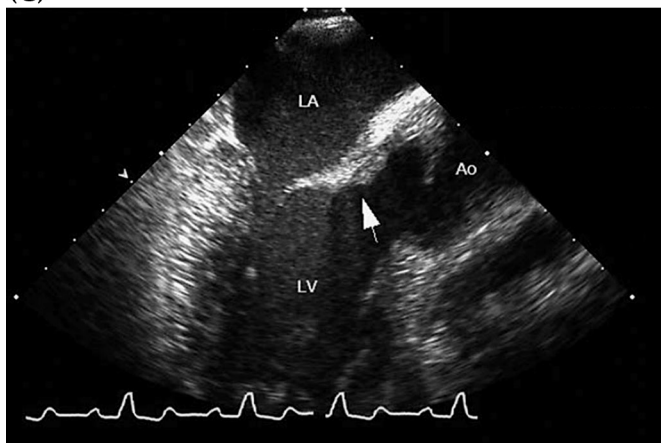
Transesophageal echocardiogram of a patient with ReA showing the aortic valve in short-axis, demonstrating diffuse thickening of the aortic wall (A; arrows) and aortic-mitral curtain (B; arrow), the so-called subaortic bump. In this particular patient, a subsequent study conducted 4 months later demonstrated massive thickening of the aortic-mitral curtain, extending to the body of the anterior mitral leaflet (C; arrow), while sparing the posterior mitral leaflet. Adapted from Novaro et al. [198].
